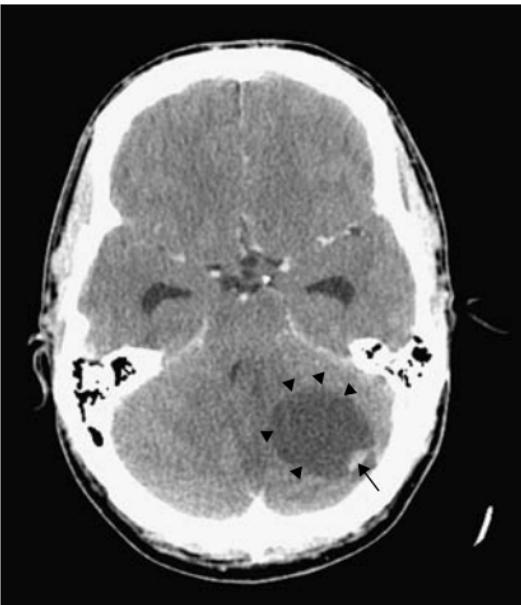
Cerebellar hemangioblastoma. (a) Non enhanced CT and (b) contrast enhanced CT. Large well circumscribed cystic mass with non-enhancing imperceptible wall ((b) black arrowheads) and enhancing mural nodule ((b) black arrow). Note the small amount of surrounding low attenuation denoting vasogenic oedema ((a) black arrowheads) and effacement of the left side of the fourth ventricle ((a) black arrow). There is resulting obstructive hydrocephalus with dilatation of the temporal horns.
